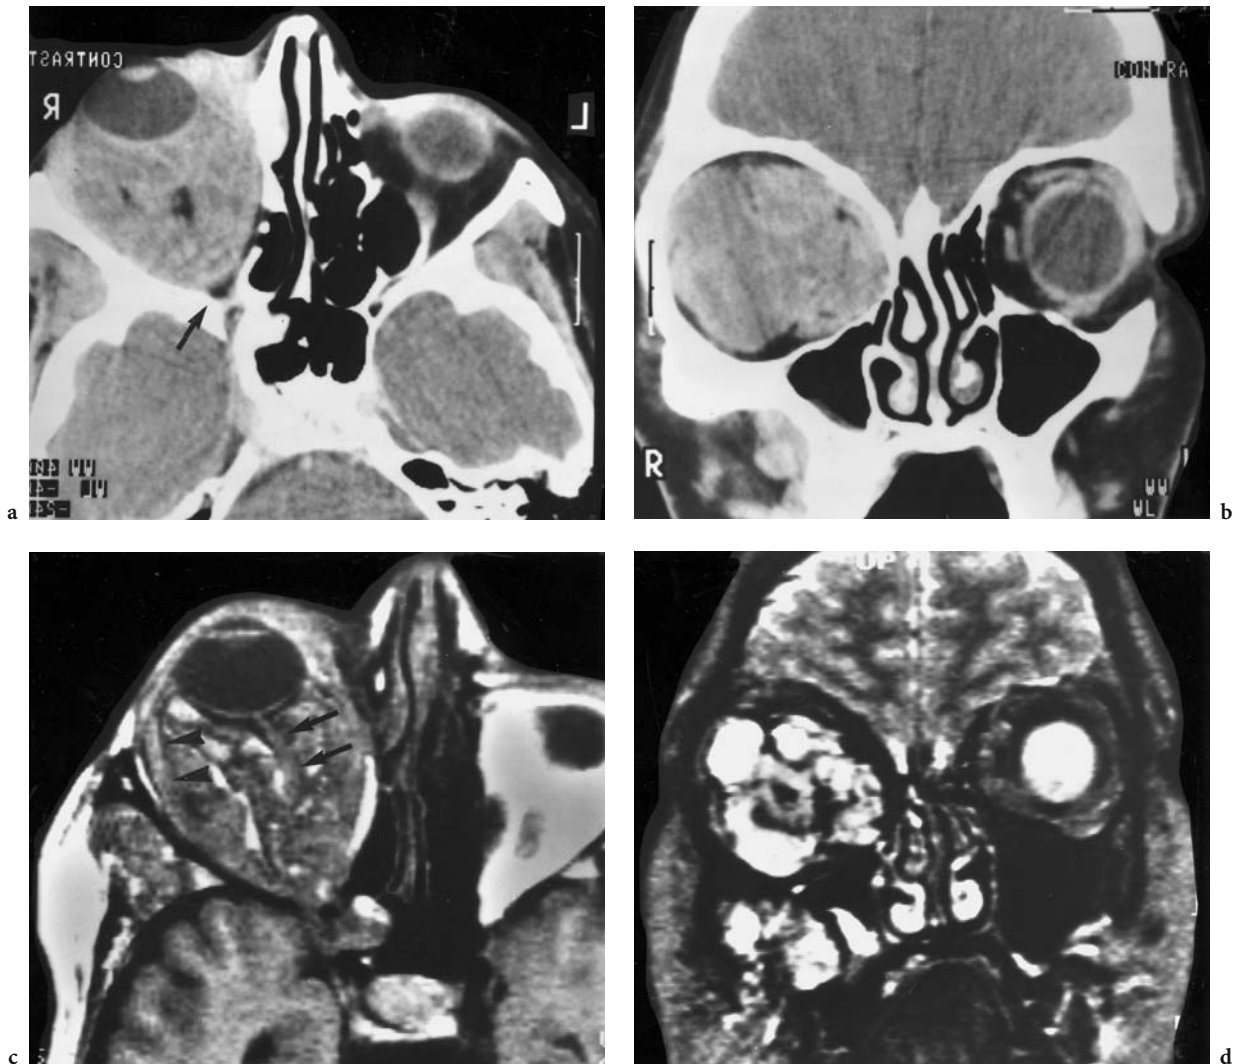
A 20-year-old woman with unilateral exophthalmos of the right eye since childhood. Diagnosis: venous lymphatic malformation. CT: a Axial contrast-enhanced view showing an enhancing, space-occupying lesion filling the entire, significantly enlarged right orbit. Note lack of identification of the rectus muscles, the still spared orbital apex, and smooth contact with the apparently normal globe. b Coronal contrast-enhanced view demonstrating severe dilation of the orbital circumference, leading to the diagnosis of a benign lesion with slow, dislocating growth. MRI: c axial T1-weighted native image, corresponding to a, showing a remnant of orbital fat as a hyperintense formation. The suspected intraconal location of the tumor is confirmed by the differentiation of the lateral rectus muscle (*arrowheads*) and the medially dislocated optic nerve (*arrows*). d Coronal T2-weighted view, corresponding to b, demonstrating a venous lymphatic malformation characterized by large, septated, liquid-filled caverns, presenting with a high signal. Note the central hypointensity, corresponding to the optic nerve not identified on CT. (With permission of MÜLLER-FORELL and LIEB 1995b)
